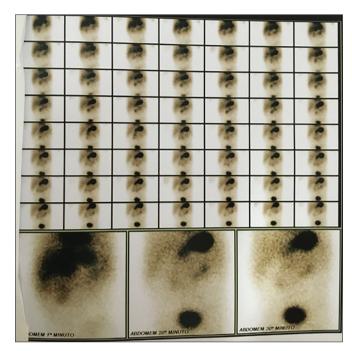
Bowel scintigraphy showing a finding indicative of ectopic gastric mucosa suggesting the presence of a Meckel diverticulum.
